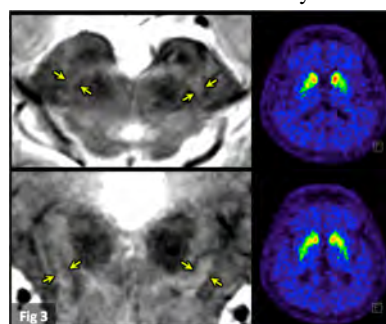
UPDRS of 6 and 3 (right and left). The right nigrosome more affected on MRI. PET shows symmetric abnormality.
